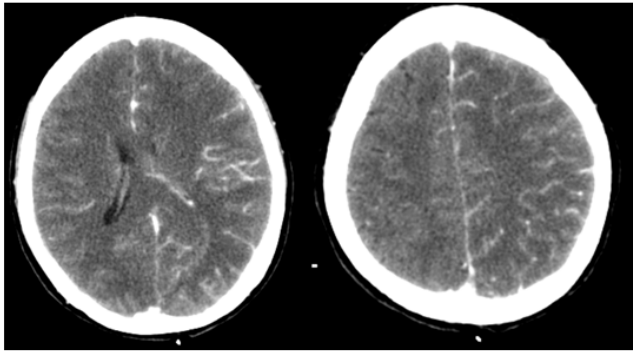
Cranial CT with contrast showing cortical enhancement of the left cerebral hemisphere.
